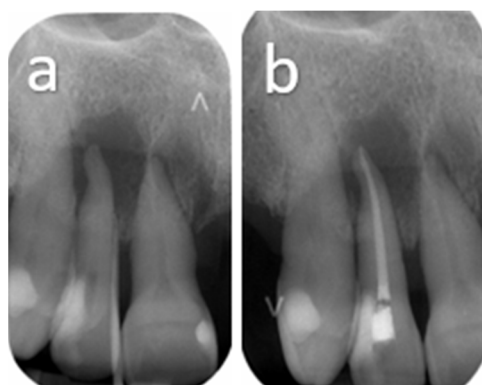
(a) Initial periapical radiograph showing a well-defined periradicular radiolucency associated with tooth 12, extending toward the adjacent interradicular area. (b) Six-month follow-up periapical radiograph after root canal treatment of tooth 12, demonstrating persistence of the periradicular radiolucent lesion without significant radiographic resolution.
